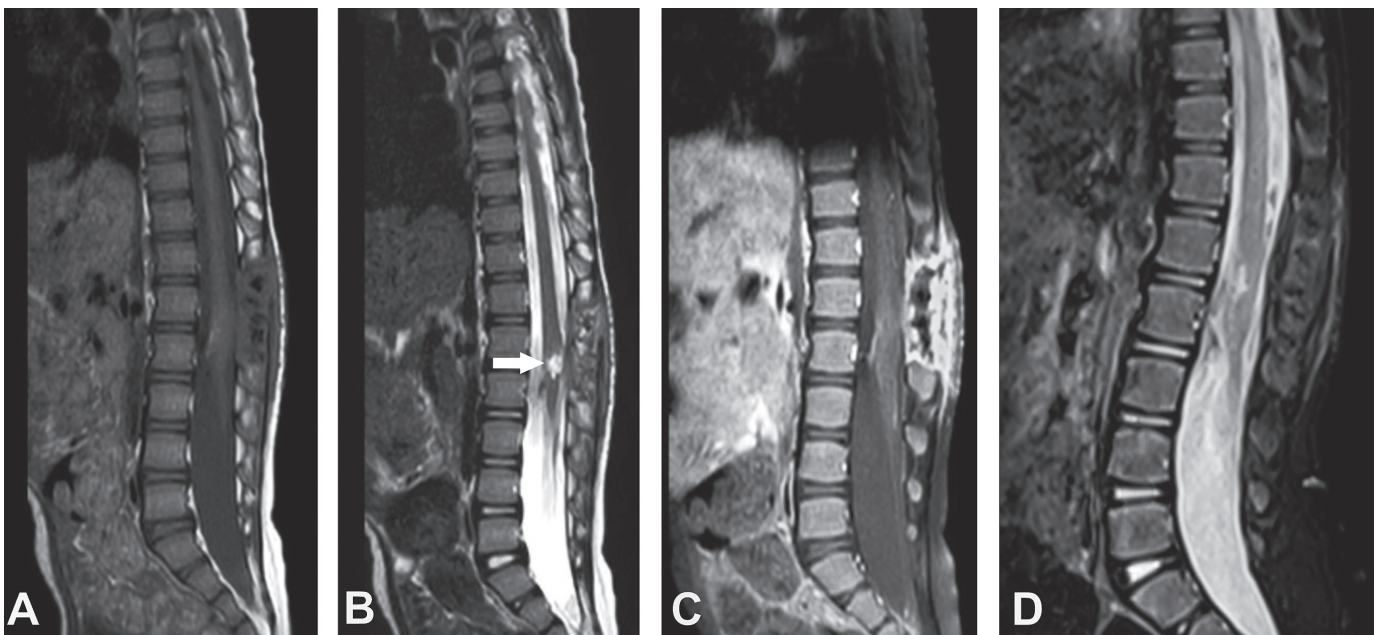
Postoperative MRIs. Disappearance of the syringohydromyelia was observed. There was no finding of residual tumor. Decompression of the conus medullaris and cauda equina fibers is shown. (A) T1-weighted, (B) T2-weighted (arrow: hyperintense image thought to be myelomalacia due to chronic compression, which existed after the cyst resection), and (C) contrasted sagittal section at 15 days postoperatively. (D) T2-weighted sagittal section also showed significant decrease of myelomalacic aspect at 60 days postoperatively.
